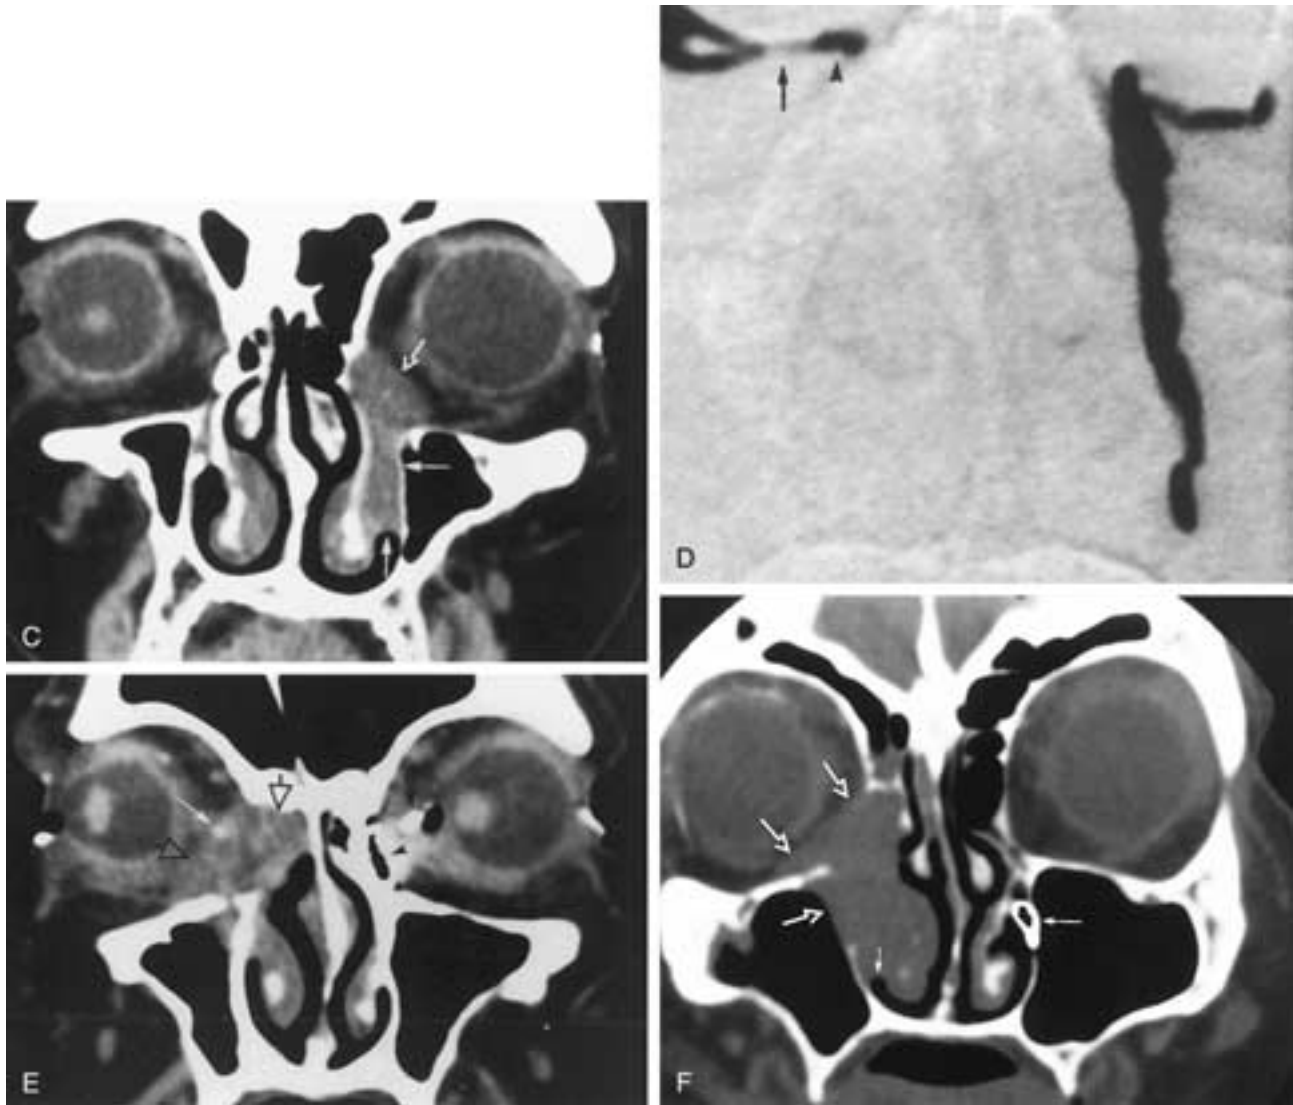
Continued.* C, More posterior coronal image shows the soft-tissue mass (open arrow) extending into and widening the left nasolacrimal canal (horizontal arrow), reaching the inferior meatus (vertical arrow). CT-DCG offered significant information beyond that available by DCG alone. Pathology: transitional cell carcinoma in the left lacrimal sac. D to F, Right inner canthus mass with epiphora. D, DCG. Superior displacement of the right proximal NLDS (arrow). Only the most superior aspect of the lacrimal sac is visualized (arrowhead). E, Coronal CT-DCG. Large soft-tissue mass (open arrows) in the right medial canthus and adjacent ethmoid sinus, with destruction of the medial orbit wall. The lacrimal sac containing contrast medium is displaced laterally and superiorly (thin arrow). Normal left NLDS (arrowheads). F, Bone windows of a slightly more posterior coronal CT scan shows extension of the mass (open arrows) along the path of the nasolacrimal canal to the inferior meatus (vertical arrow) with adjacent bone destruction. Contrast material in the left inferior meatus (horizontal arrow). Pathology: squamous cell carcinoma.
